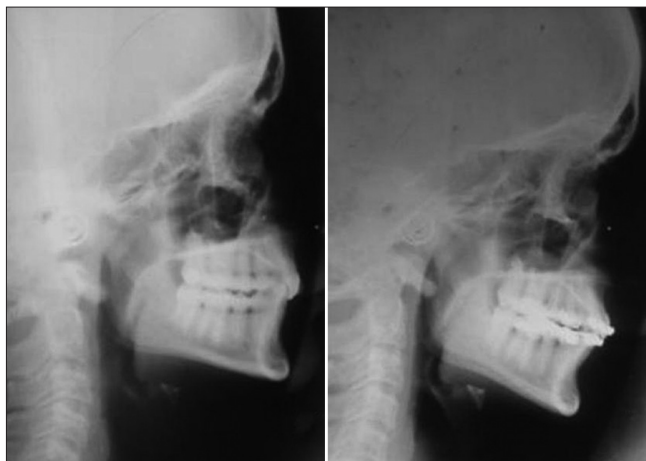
Radiographs of orthodontic treatment of deep bite patient with class II division 2 malocclusion
